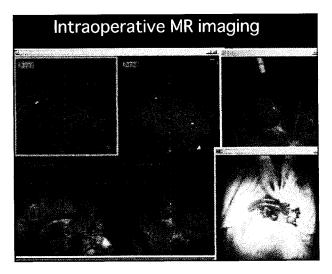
Intraoperative MR image monitor. Real-time image with a biopsy needle is shown every two seconds alternately switching between the two planes perpendicular each other (upper left and center). Higher quality image reconstructed from the updated 3D volume data on the same plane as the real-time one is shown at the same time (lower left and center). Biopsy sites are marked on the 3D image (upper right). Monitor of operative field (lower right)
